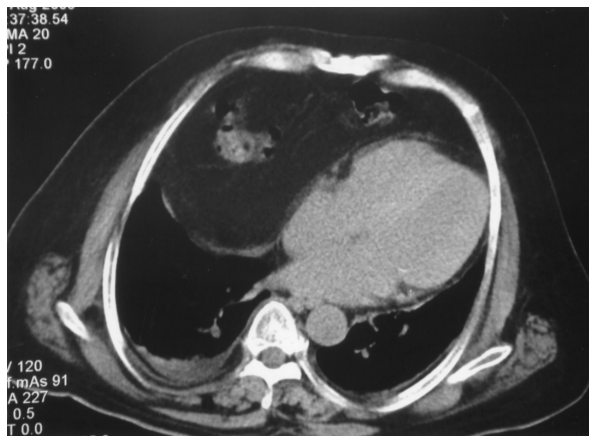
Computed tomographic scan shows a right retrosternal hernia containing both omentum and colon. The heart is compressed by the hernia sac and shifts to the left side of the thorax.
